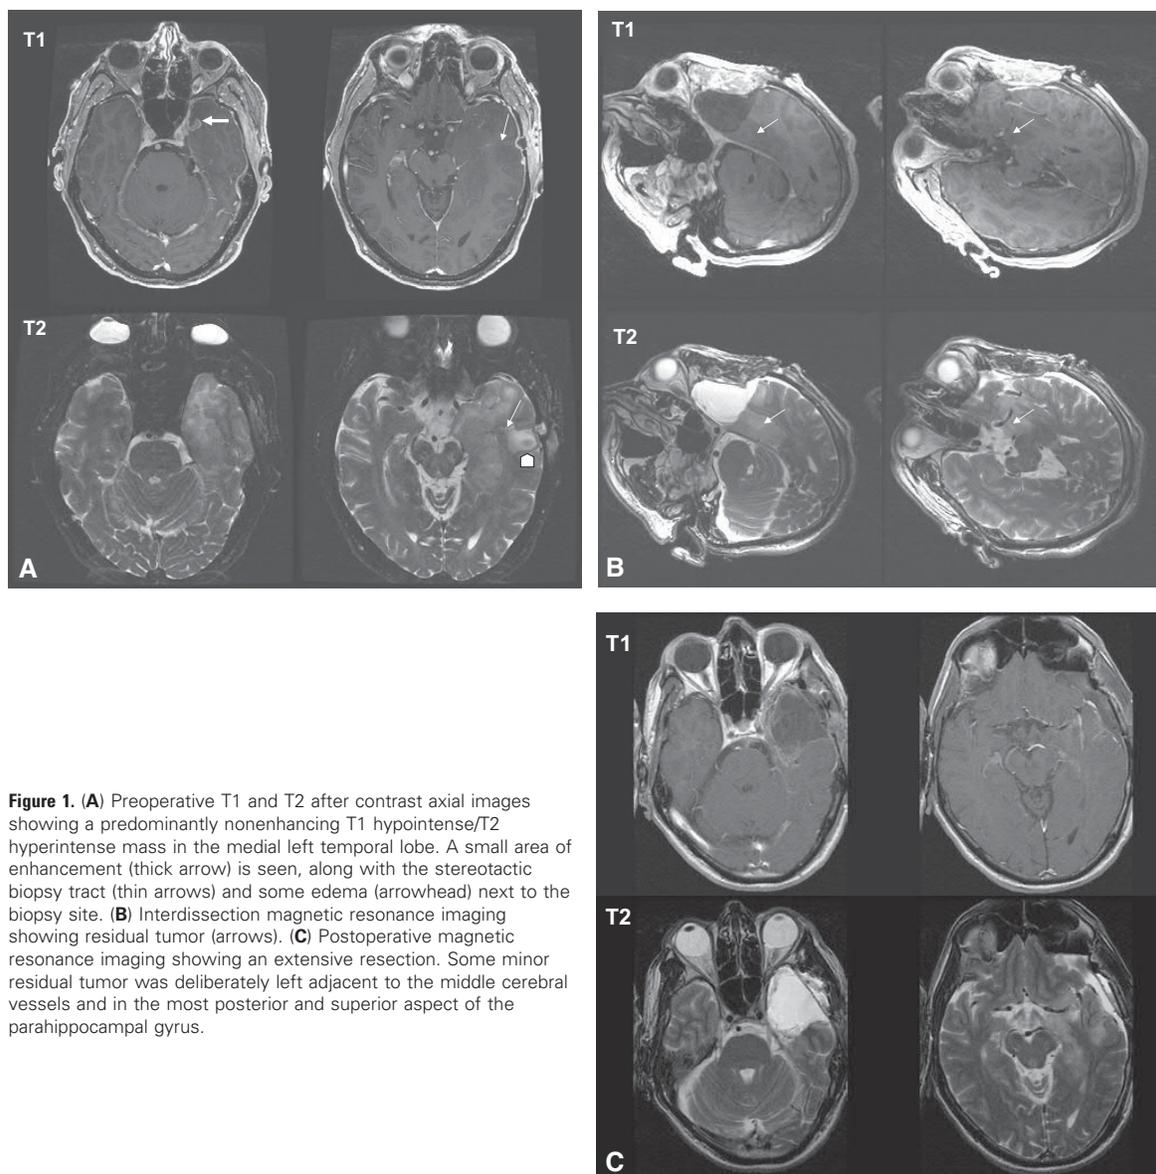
(A) Preoperative T1 and T2 after contrast axial images showing a predominantly nonenhancing T1 hypointense/T2 hyperintense mass in the medial left temporal lobe. A small area of enhancement (thick arrow) is seen, along with the stereotactic biopsy tract (thin arrows) and some edema (arrowhead) next to the biopsy site. (B) Interdissection magnetic resonance imaging showing residual tumor (arrows). (C) Postoperative magnetic resonance imaging showing an extensive resection. Some minor residual tumor was deliberately left adjacent to the middle cerebral vessels and in the most posterior and superior aspect of the parahippocampal gyrus.
